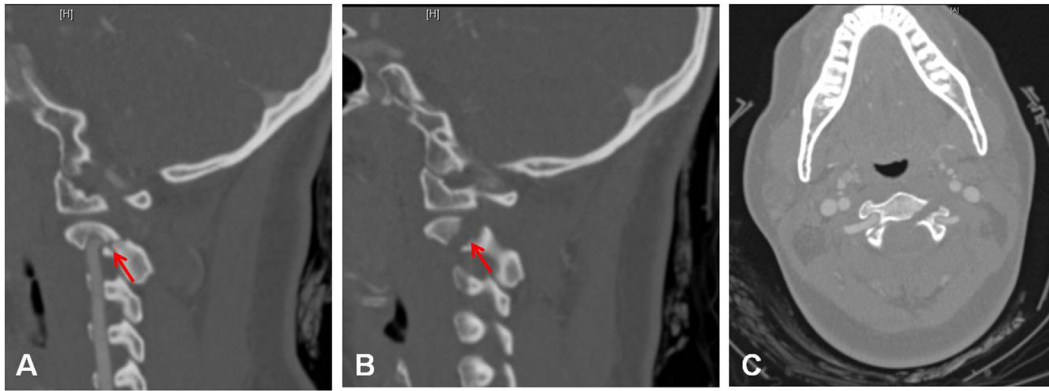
A 21-year old female suffered a motor vehicle accident. Spinal precautions were maintained at the scene and she was transported to the emergency room at our hospital. She complained of neck pain and her neurological examination was normal. A Computer tomography scan was obtained revealing a Hangman's fracture type 1. Note the bilateral pars interarticularis fractures on the sagittal CT reconstruction (A, B, Arrows), as well as the axial CT (C). The patient was placed in a crown halo vest.
